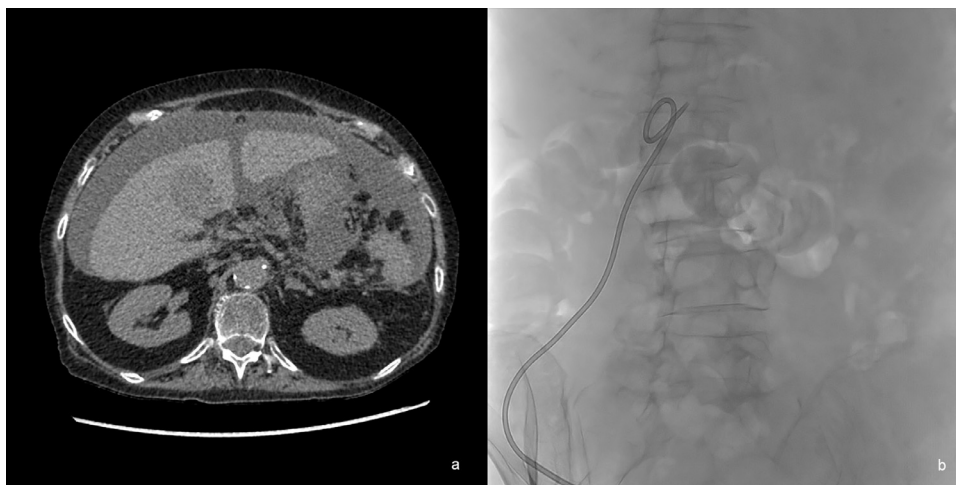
CT scan in axial plane showing malignant ascites from primary ovarian neoplasm with peritoneal carcinosis (a). Fluoroscopy showing peritoneal catheter drainage (b).
